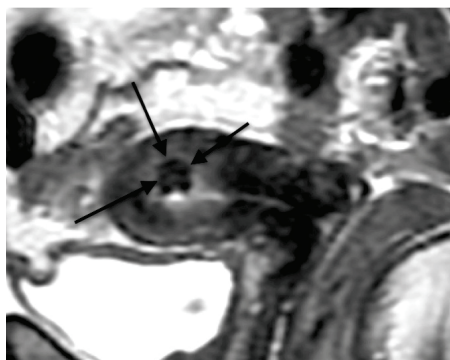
MRI showing shrunken "scarred" adenomyoma post UAE.
